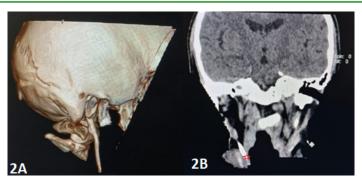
(A) Long styloid process on 3D CT (B) Elongated styloid process on the non-contrast CT.
